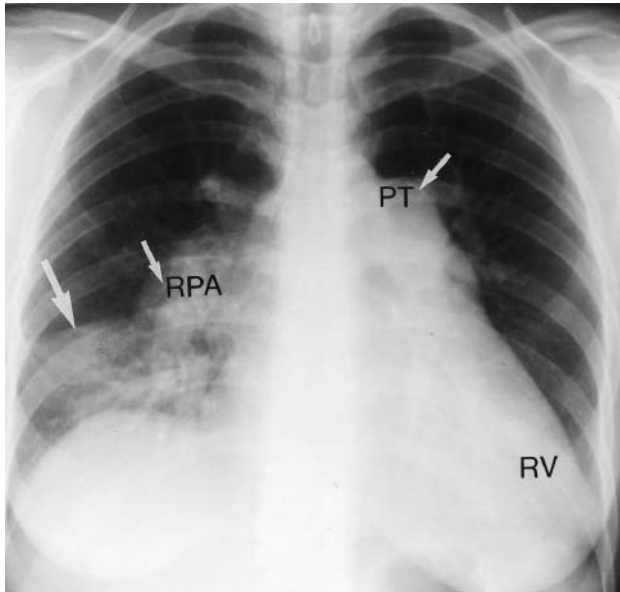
X-ray from a 40-year-old woman with pulmonary hypertension and an atrial septal defect. Embolization of thrombus in the dilated calcified right pulmonary artery (RPA) caused a hemorrhagic right pleural effusion (large arrow). The pulmonary trunk (PT) is dilated, and an enlarged right ventricle (RV) occupies the apex.
